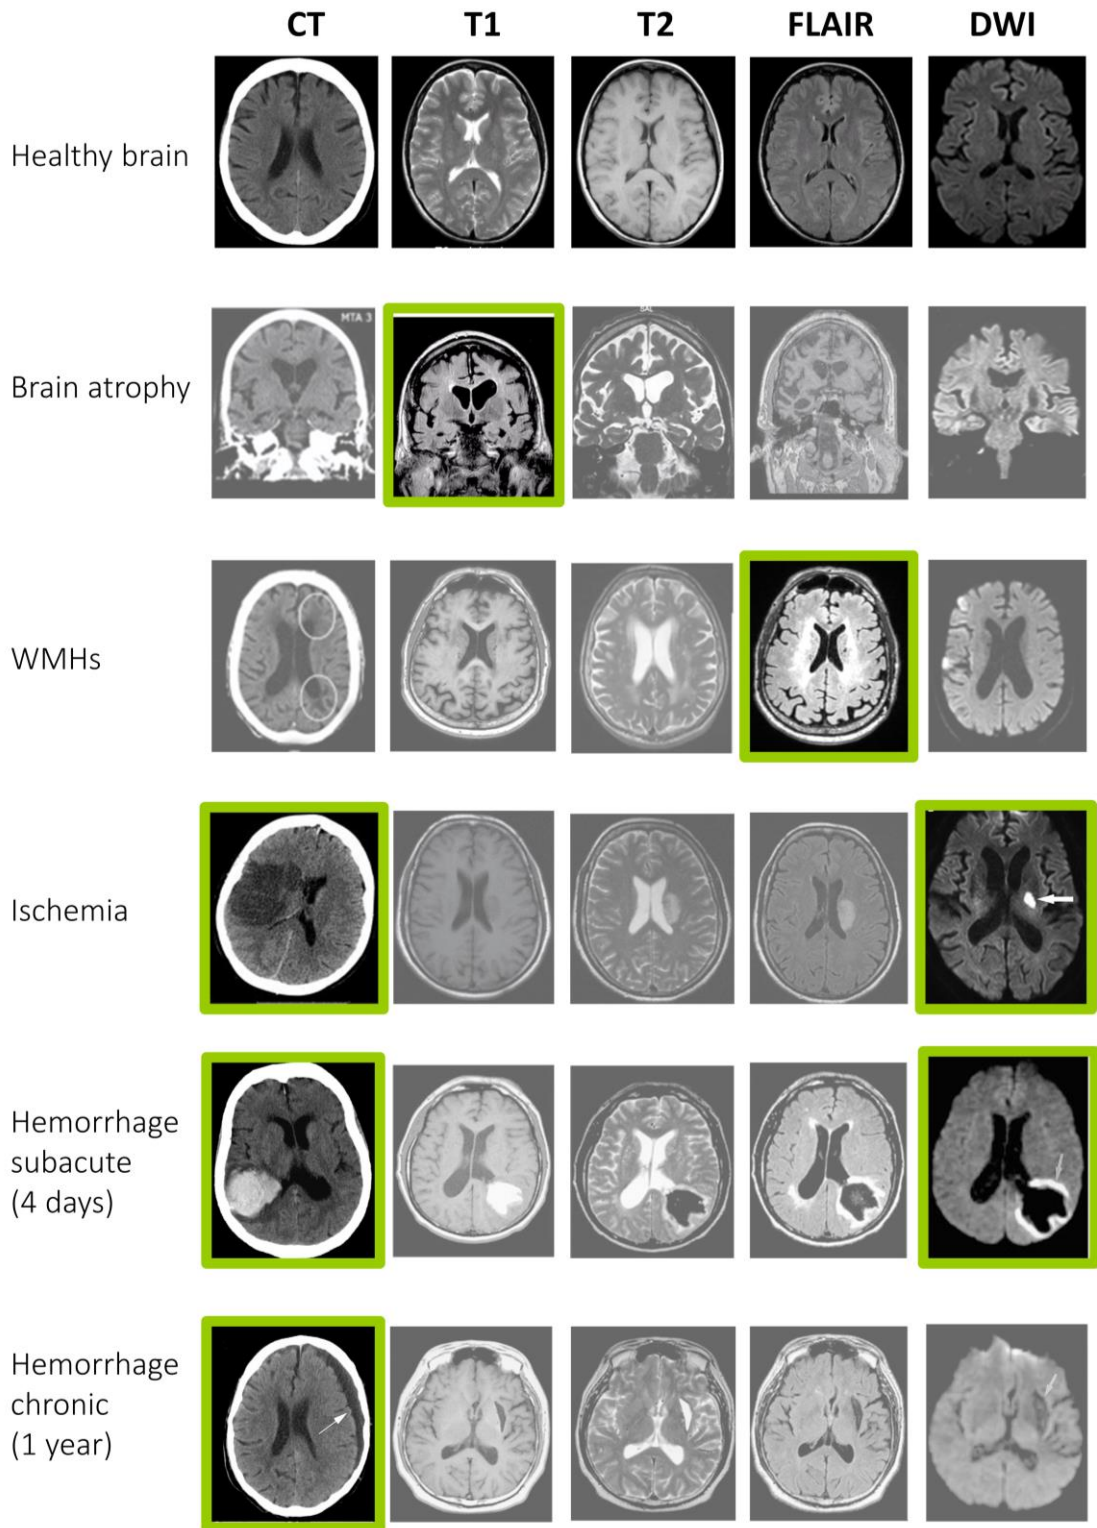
Structural neuroimaging overview of the main type of vascular damages described in the VICCCS-II neuroimaging guideline for VCI diagnosis. These damages are shown for the main structural neuroimaging techniques described before. Rows from left to right: computerized tomography (CT) and magnetic resonance imaging in four sequences (T1, T2, Flair and DWI). The green squares indicate the most appropriate technique for detecting each vascular damage.
